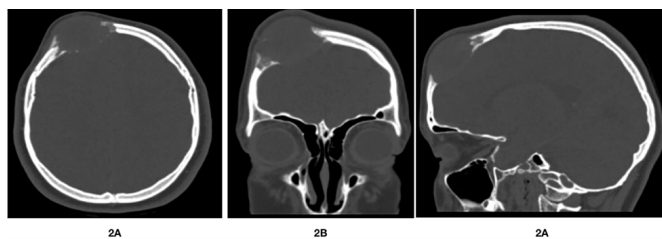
Head CT scan bone window images reveals an irregular destruction and erosion of both tables of the vault.
